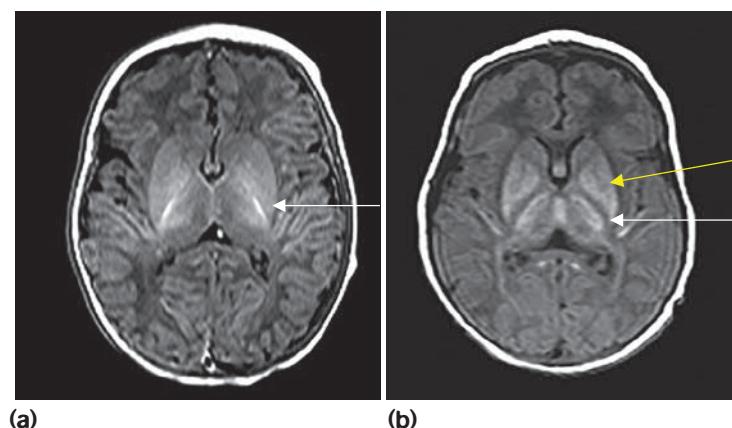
Magnetic resonance image (T1 in axial view) of the brain at 14 days in a term infant. (a) Normal scan for comparison, showing high signal in the posterior limb of the internal capsule (PLIC) (arrow). (b) Following severe HIE, showing loss of the normal high signal from myelin in the internal capsule (PLIC) (white arrow) and abnormal high signal in the adjacent basal ganglia and thalamus (yellow arrow). These findings would be associated with a severe motor impairment in the form of cerebral palsy, poor head growth, persistent feeding difficulties, seizures and marked cognitive impairment. (Courtesy of Professor Mary Rutherford.)
